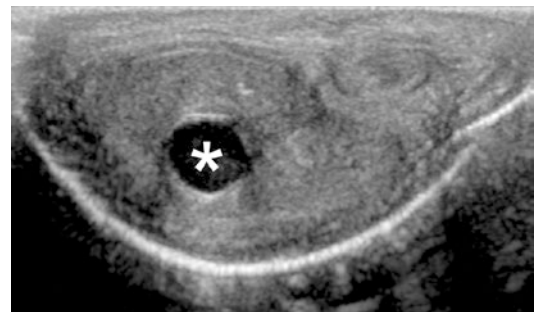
Isolated septal haematoma. The patient presented with a lump in the mid-shaft 10 days after severe bending of the erect penis during intercourse associated with pain. Axial ultrasonographic scan shows a well-defined cystic-like lesion within the septum (*asterisk*), consistent with posttraumatic haematoma
